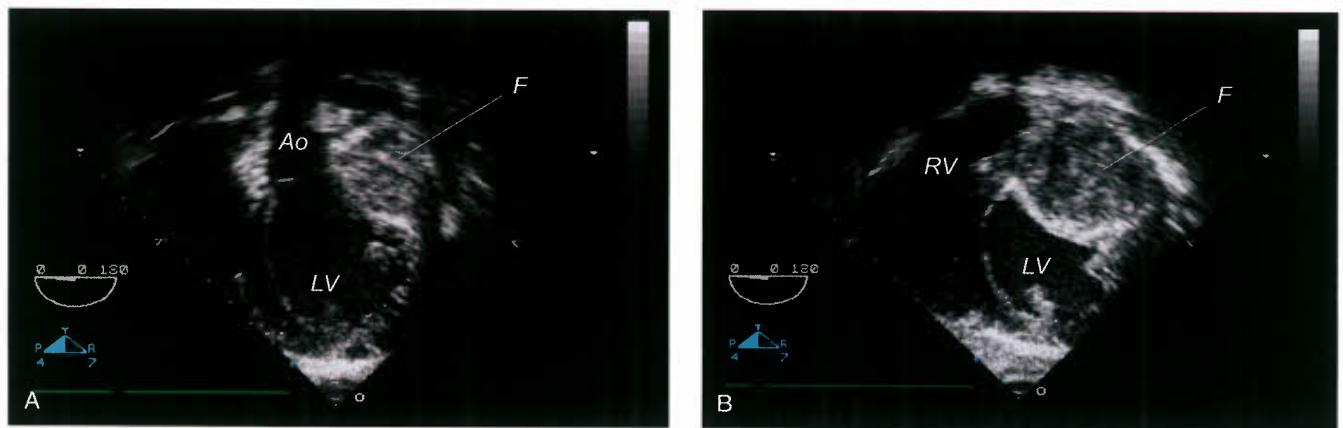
Two-dimensional echocardiogram in a 2-year-old child with a large left ventricular fibroma (F). A: Long-axis plane showing homogenous encapsulated intramural mass extending from the left ventricular posterior wall into the cavity. B: Corresponding orthogonal short-axis plane in same patient. Ao, aorta; LV, left ventricle; RV, right ventricle.
